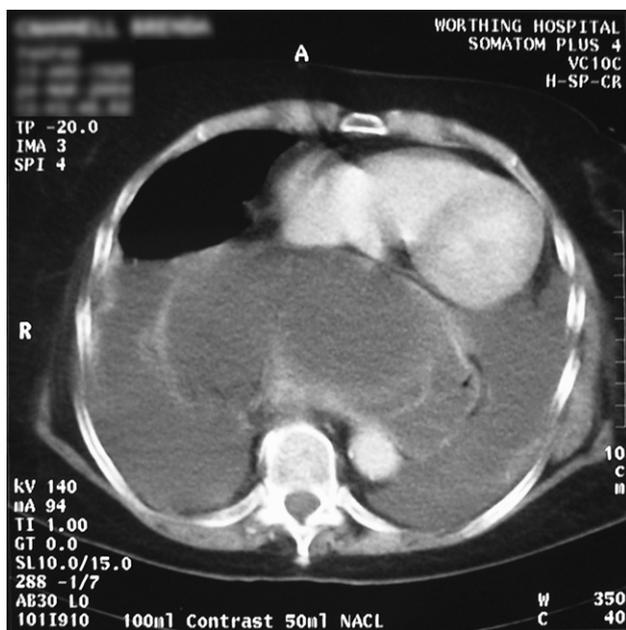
A CT scan of the chest which shows a large well defined fluid filled structure representing a gastric volvulus in the posterior mediastinum.
